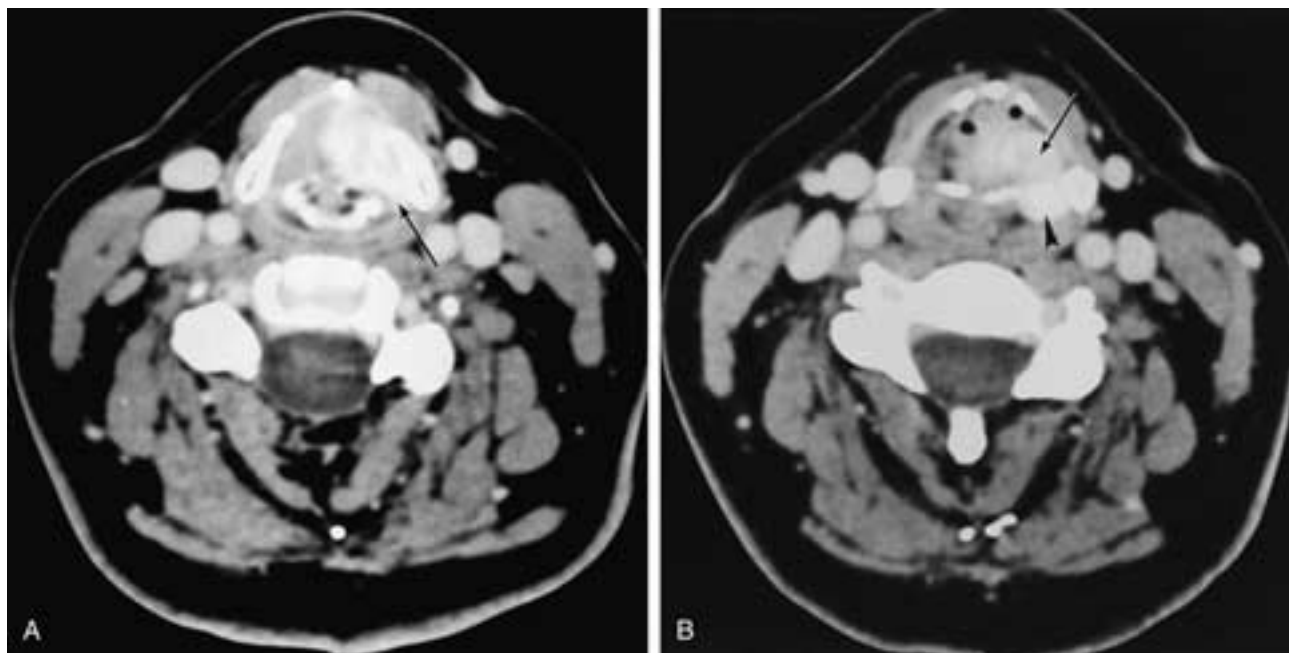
Axial CT. A, Radiopaque Teflon injected into the cord. Note the small amount of Teflon (*arrow*) squeezing between the thyroid cartilage and the arytenoid. B, Supraglottic scan. The radiopaque Teflon (*arrow*) again squeezes between the thyroid cartilage and the upper arytenoid (*arrowhead*). This amount of Teflon is more than is usually seen in a routine injection.
